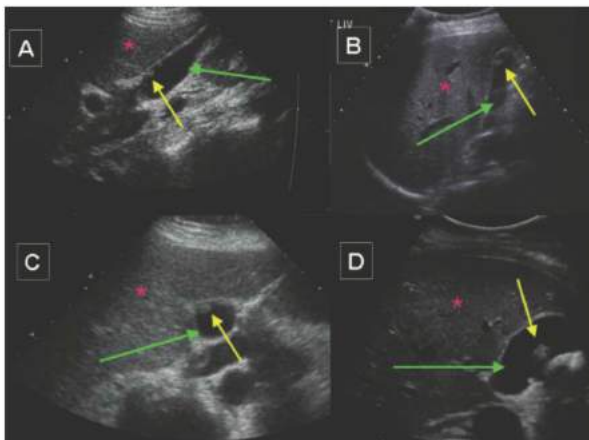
• Longitudinal (A,B) and transverse (C,D) ultrasonographic imaging of the gallbladder. A polypoid mass (yellow arrows) is seen within the gallbladder lumen (green arrows). The relationship of the polypoid mass to the liver (red asterisks) can be roughly determined as in A–C, likely adjacent to the hepatic fossa, or D, likely on the peritoneal/free aspect of the gallbladder.
